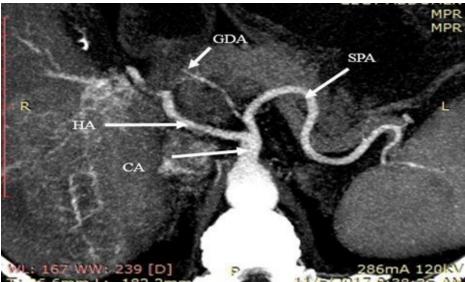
CT Angiogram, axial MIP image showing Gastroduodenal artery arisingfrom Splenic artery [Absent Common hepatic artery
